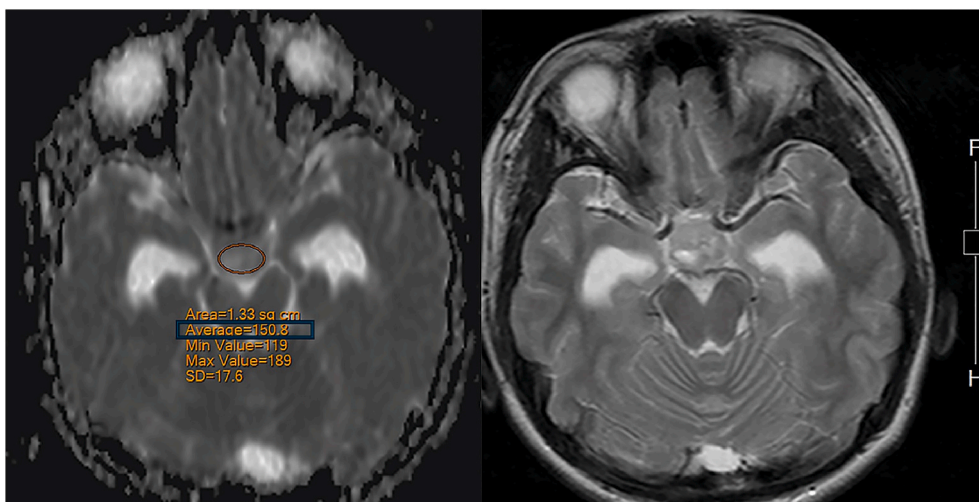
A 13-year-old male with a suprasellar germinoma. To measure the ADC value of the "whole tumor," the slice with the largest tumor diameter on the axial view was selected. An ovoid region of interest (ROI) was then placed on the ADC map, aiming to be as large as possible without exceeding the tumor's margin. We utilized the average value in the measurement data (the rectangular box in the image, which is presented identically in Fig. 2b and c). The T2-weighted image at the same level served as a reference.
